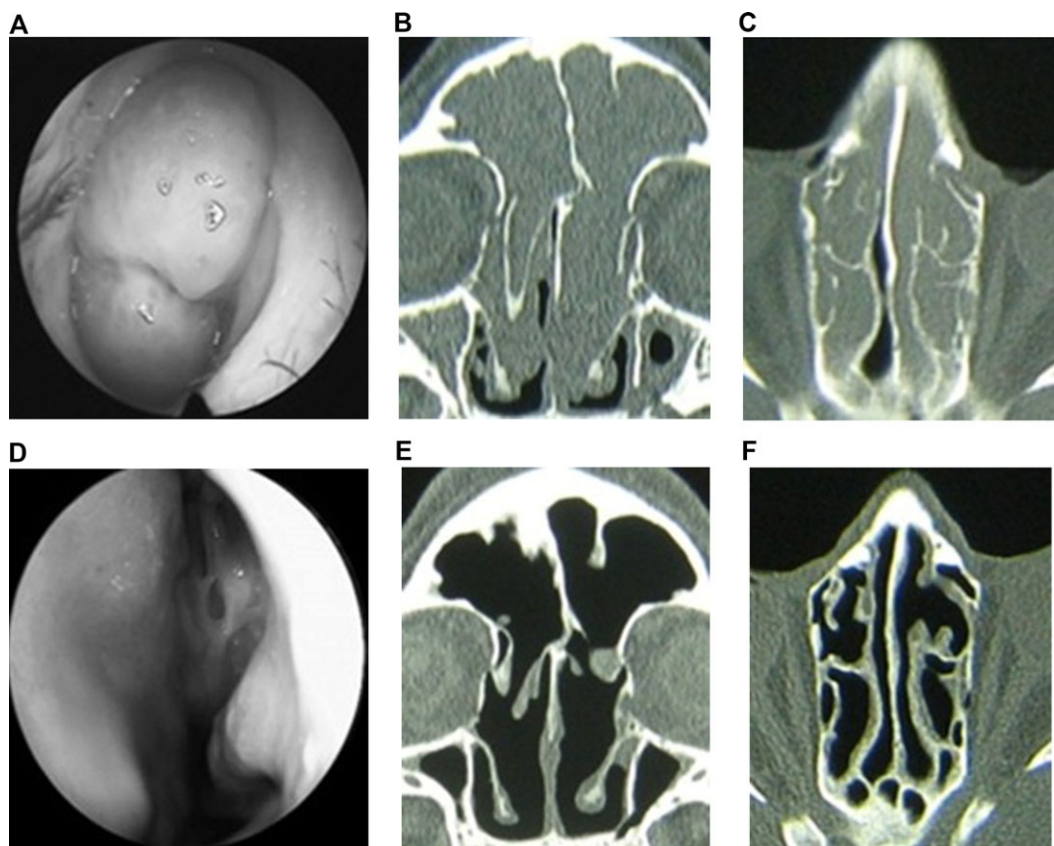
Endoscopic appearance and CT scans of 26-year-old male patient (CRSwNP, bronchial asthma, 5 previous sinus surgeries) before and after FESS followed by 6-month course of low-dose clarithromycin therapy. Before FESS: (A) large polyps completely block left nasal cavity; (B, C) total opacification of paranasal sinuses and signs of osteitis on axial and coronal CT scans. Six months after FESS: (D) no visible polyps, multiple synechia in the left ethmoid cavity; (E, F) sinuses are pneumatized, slight thickening of the ethmoid mucosa. CRSwNP = chronic rhinosinusitis with nasal polyposis; CT = computed tomography; FESS = functional endoscopic sinus surgery.
